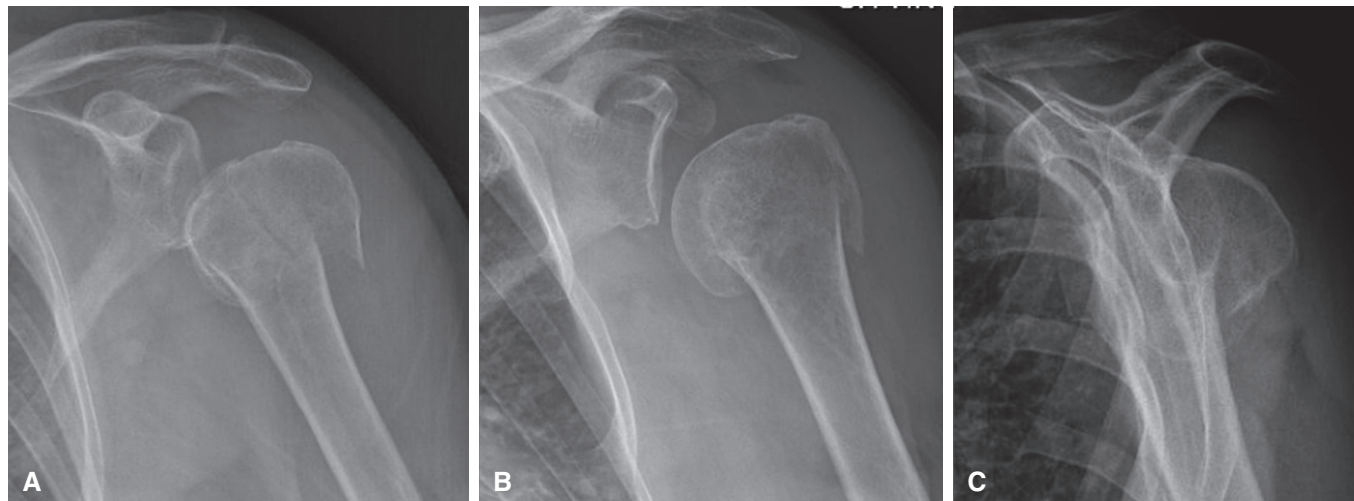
Anteroposterior (A), Grashey (B), and scapular-Y (C) radiographs of a left proximal humerus fracture.
